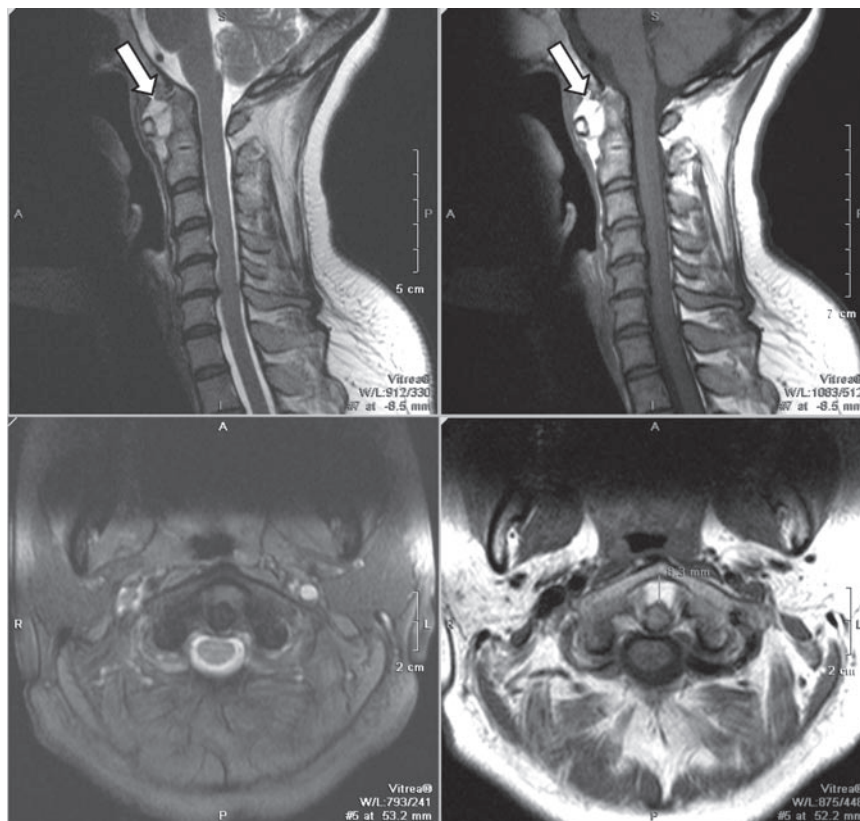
T2W sagittal & axial (left) and T1W sagittal & axial (right) MR images of the cervical spine. Widening of the atlanto-axial interval is seen (8.3 mm) which is filled by fatty tissue (white arrows). Incidental finding of spondylotic changes with multiple intervertebral discs protrusions are seen. No significant cord compression is detected.
